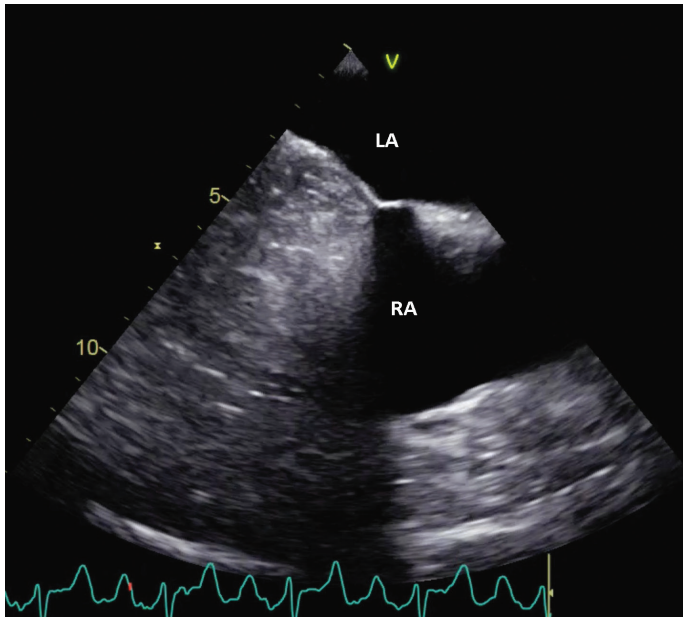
Transoesophageal echocardiographic image of the dumbbell-shaped mass sparing fossa ovalis
